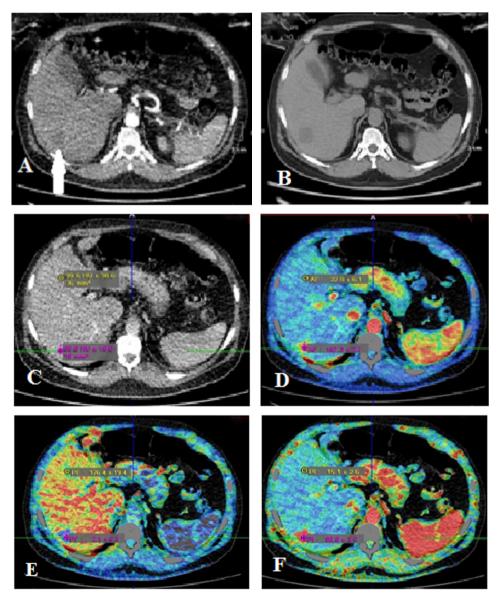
Triphasic CT examination shows segment VII focal lesion (white arrow) with faint arterial enhancement in A and delayed contrast washout in delayed phase in B. C-F: CTP shows CT attenuation value of the focal lesion in first pass perfusion of contrast displays nearly the same attenuation value of the normal hepatic parenchyma (focal lesion = 85.6 HU, surrounding parenchyma = 99.6 HU), with high (AF) in D, low (PF) in E with high (PI) in F in relation to the surrounding hepatic parenchyma evident by the color mapping. Diagnosis: Right hepatic lobe HCC.
